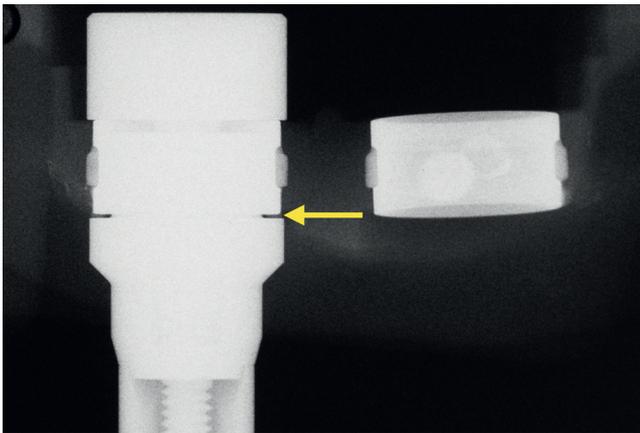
Radiograph confirming incomplete adaptation.
